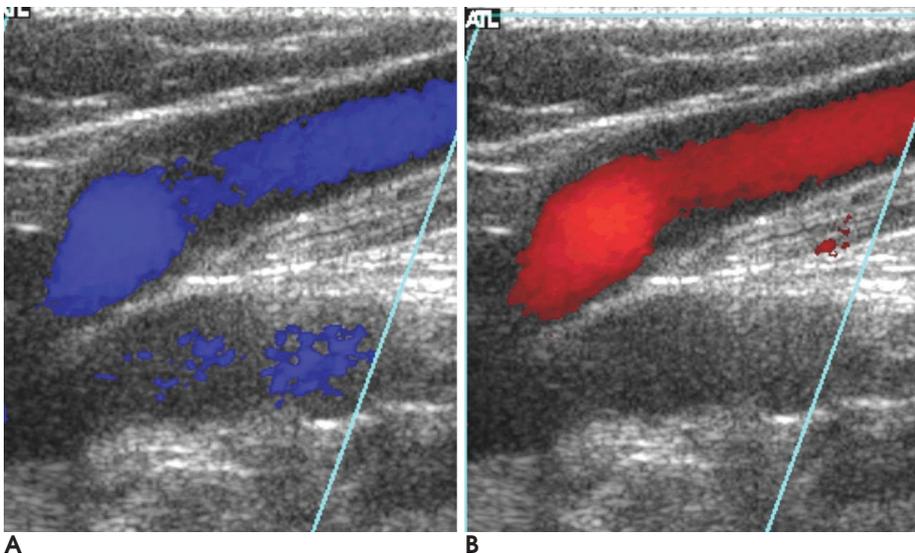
Grade IV reflux : a. Color Doppler image of small saphenous vein in resting state. b. The reflux is detected at resting state in small saphenous vein.
